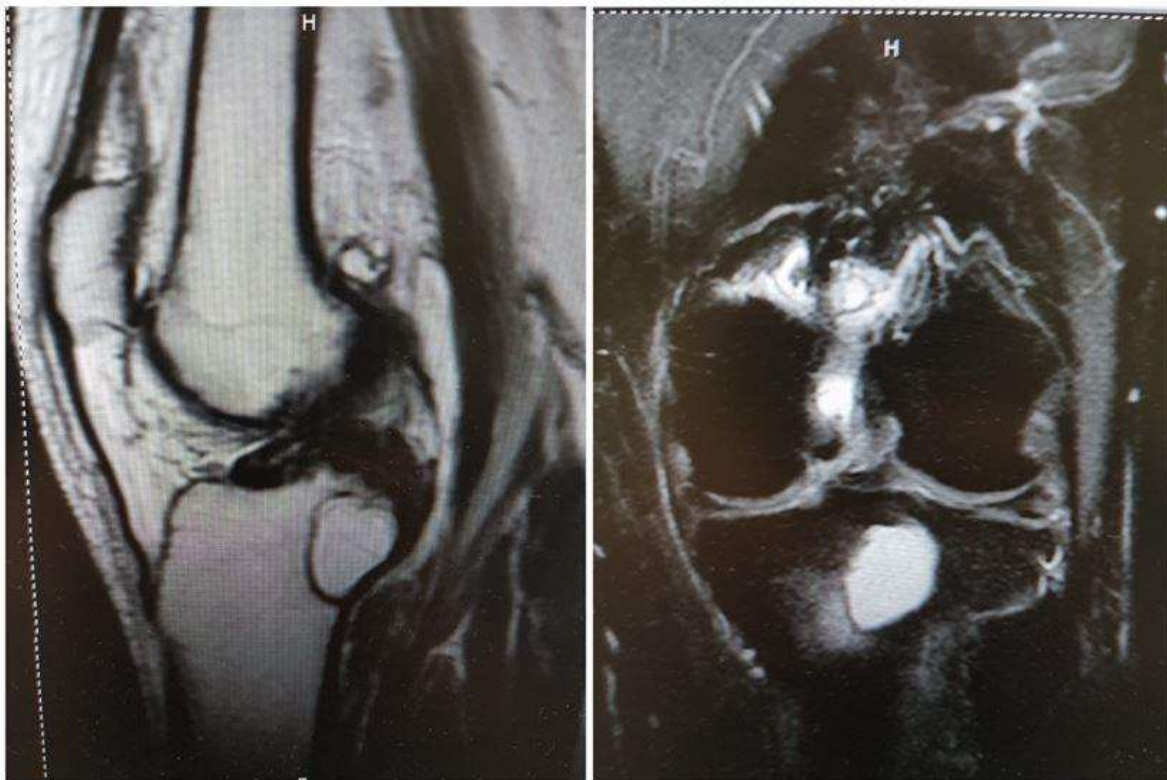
Cystic lesion on knee MRI imaging.
